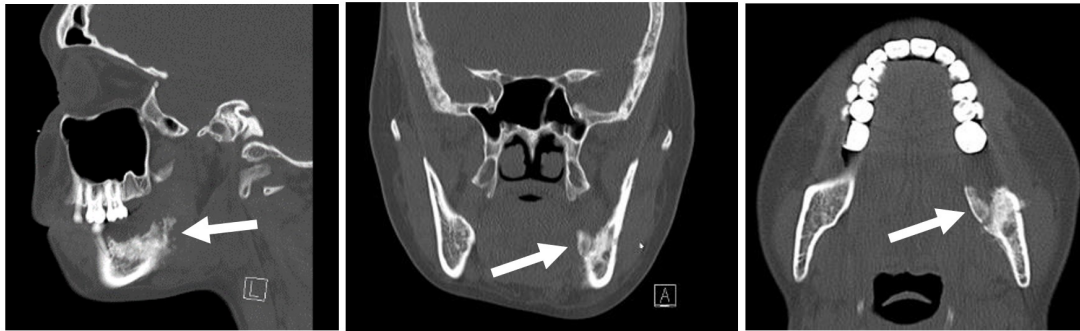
CT: medullary sclerosis, cortical erosion and periosteal reaction (white arrow).
